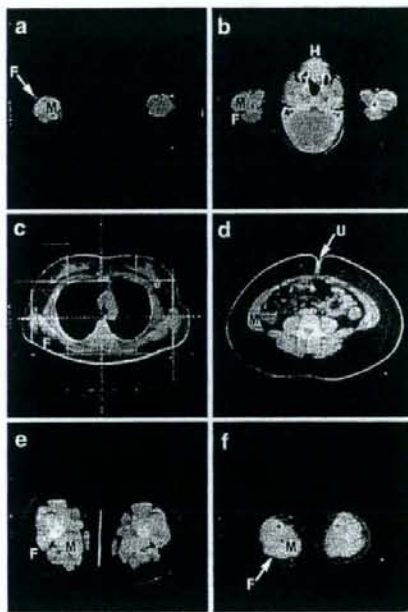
Our first report of fat analysis using computed tomography. Adapted from Tokunaga *et al.*⁴
